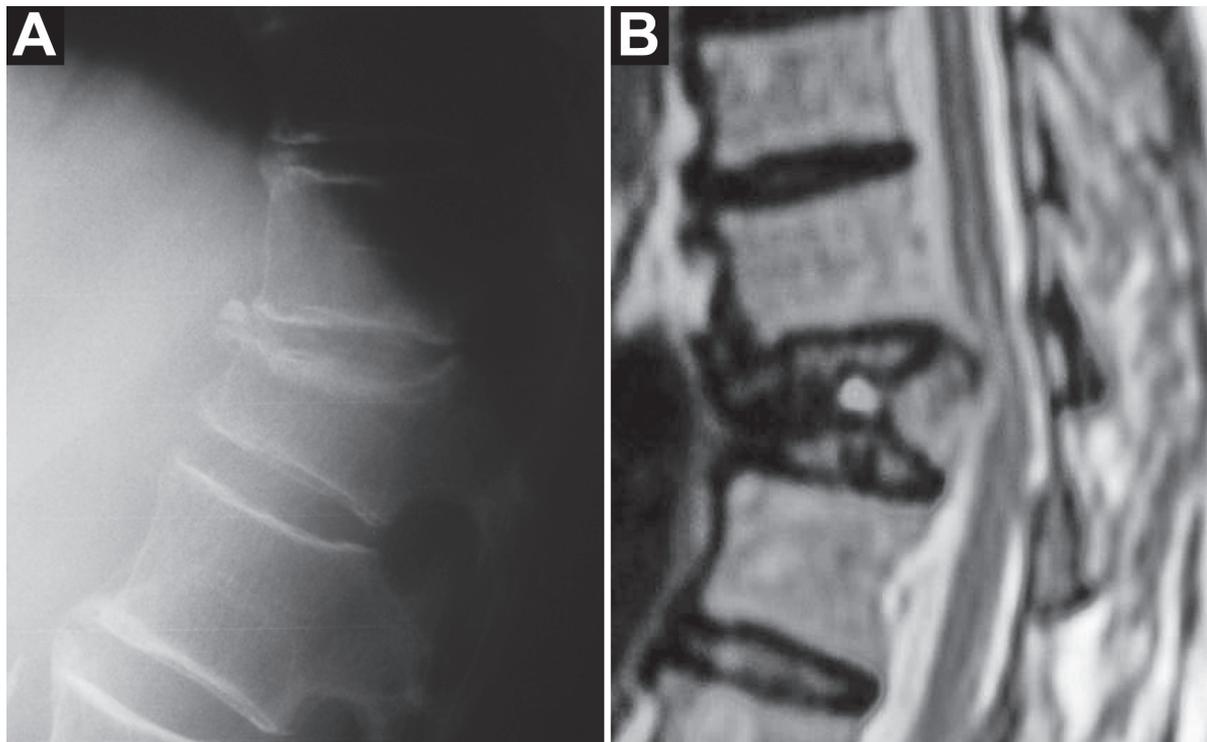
Delayed collapse of pseudarthrotic wedge fracture complicated with kyphosis, retropulsion of posterior vertebral wall fragment and paraparesis. This could have been prevented with kyphoplasty. (A) plain X-rays; (B) MRI scan.
